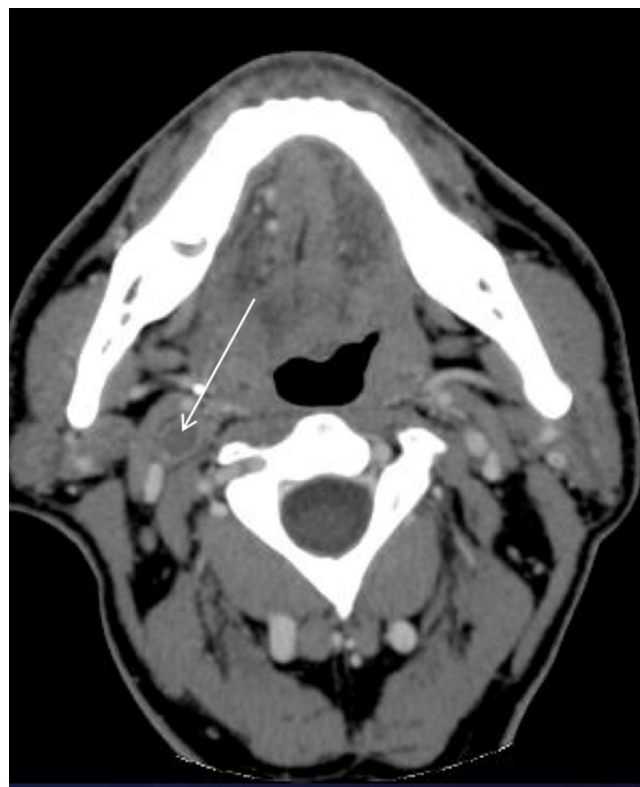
CT angiography. Case 1. Marked widening of the right internal carotid artery; about 15 mm above the division of the completely occluded vessel (no contrast enhancement). Device – CT Toshiba Aquilion 16.
